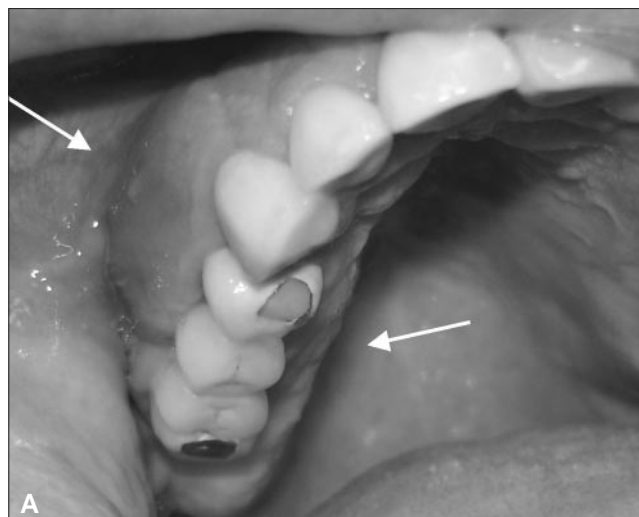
Initial presentation. A. Observe area of swelling on the right maxillary arch on both buccal and palatal aspects (arrows). B. Periapical radiograph of the area showing the presence of a radiolucency at the apex of tooth # 5 (arrow).
